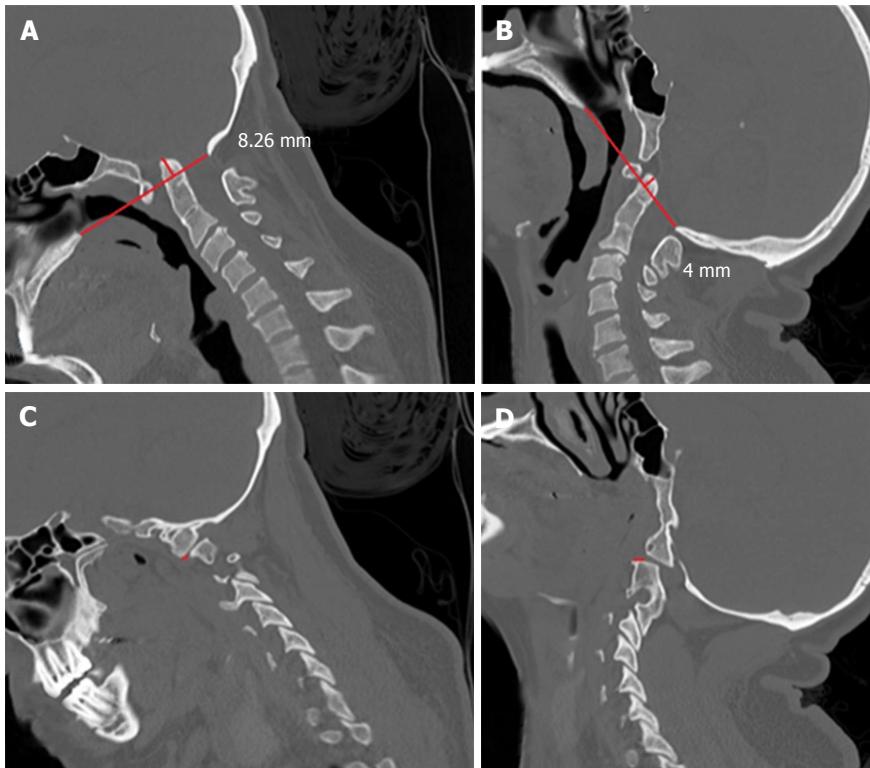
A 18-year-old woman with basilar invagination and tonsillar herniation of 7 mm. She also had atlas assimilation. A: Sagittal computed tomography (CT) scan in flexion shows the tip of the odontoid 8.26 mm above the Chamberlain's line; B: Sagittal CT scan in extended position shows the tip of the odontoid 4 mm above the Chamberlain's line; C: Sagittal CT scan showing anterior dislocation of the facet joint of C1 over C2 facet of 2 mm; D: Sagittal CT scan showing posterior dislocation of the C1 facet joint over the facet of C2 of 3 mm, ranging 5 mm in dynamic exam. This patient underwent a craniocervical fusion concomitant to the posterior fossa decompression.
